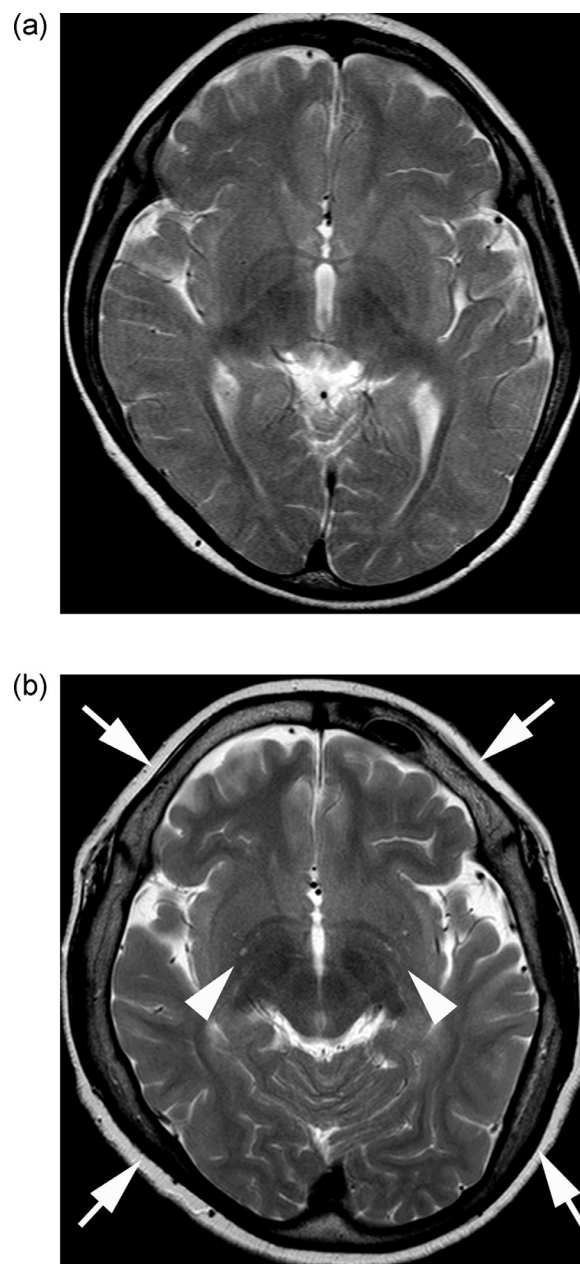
Axial T2-weighted imaging at (A) 6 years and (B) 12 years of age showing progressive cranial hyperostosis (arrows) and worsened cerebral atrophy with faintly dilated perivascular spaces (arrowheads).
